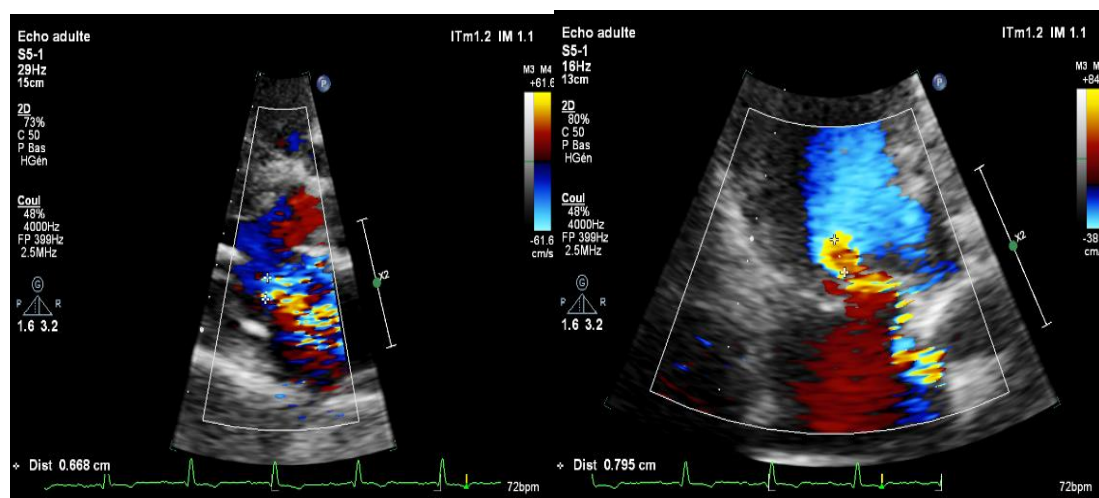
Transthoracic echocardiogram apical four-chamber and parasternal long-axis view showed a moderate mitral regurgitation
